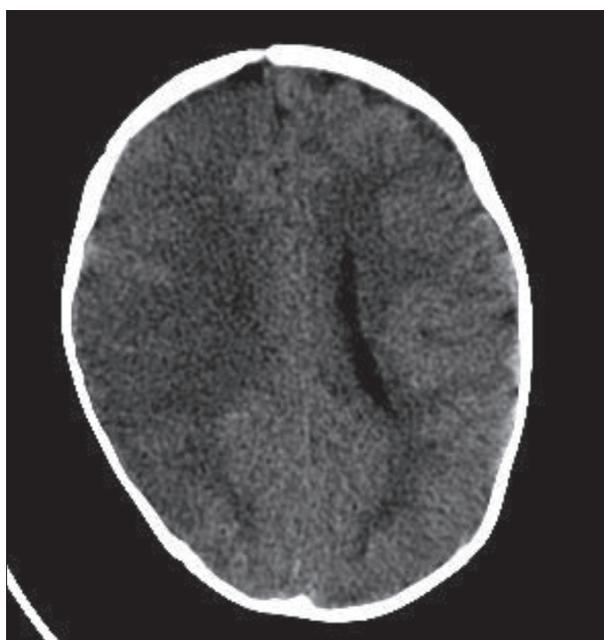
Brain computed tomography scan during hemiconvulsive status epilepticus, showing right cerebral edema
